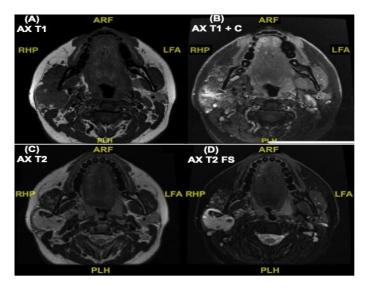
Axial MRI cuts at the middle of the second component of the lesion, located deeply in the parapharyngeal pre-styloid space. (A) Axial T1-weighted MR image revealing a well-defined hypointense lesion that contains multiple cystic components with vascular content and several nodules corresponding to phleboliths. (B) Axial T1-weighted MR image with contrast showing the same image as (A) but with intense
